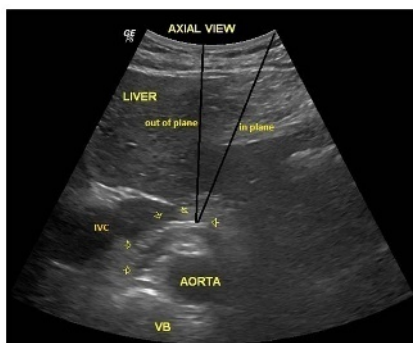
Cross-sectional sonographic image showing injectate spread (arrowheads). IVC indicates inferior vena cava; VB, vertebral body. Black lines show needle trajectory for an out-of-plane approach and in-plane approach.
